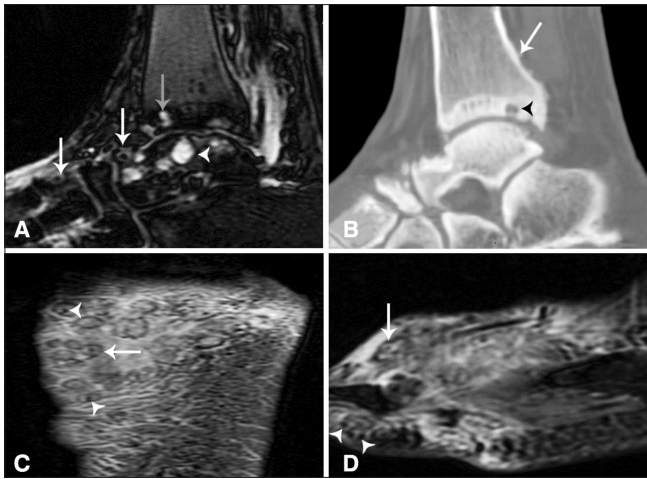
(A-D): Sagittal short-Tau inversion recovery (STIR) MRI image (A) shows osteolytic areas in the tibia (grey arrow) and talus (white arrowhead); “dot-in-circle” lesions (white arrows) are seen in the soft tissue. Sagittal CT scan (B) shows osteolytic areas (black arrowhead) and periosteal reaction (white arrow) in the tibia. Axial T2W MRI image through the sole of the foot (C) and sagittal T2W MRI image (D) show multiple T2-bright round lesions (white arrow) with a central dot (white arrowheads), seen clearly in some lesions and faintly in others
